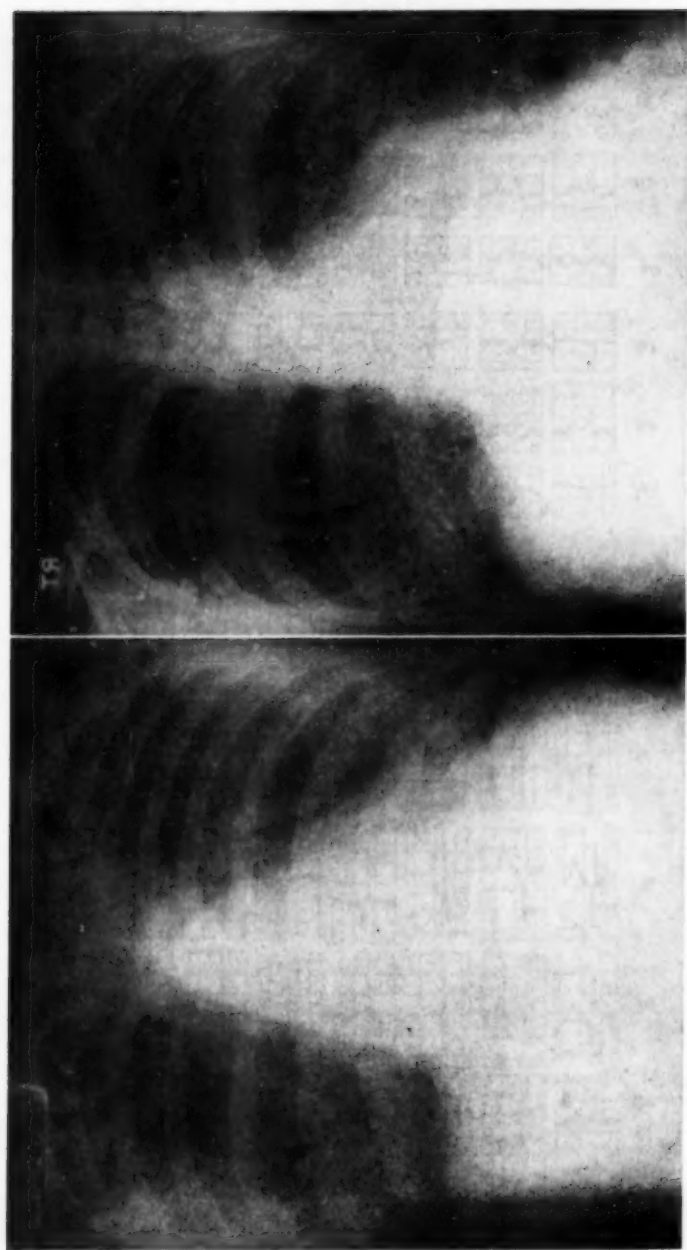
A. Portable AP x-ray of the chest on the second hospital day. Note the extensive diffuse nodular infiltration in all lung fields. B. Considerable clearing of the nodular infiltration is present on the fifth hospital day.
